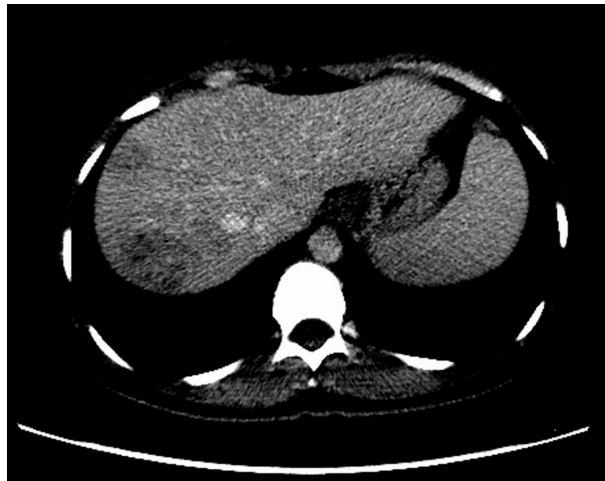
Computed tomography image after contrast medium injection. Axial computed tomography image revealed that hypodense and heterogenous lesions with soft tissue density of maximally 40 mm × 33 mm in diameter in the right lobe of the liver.
